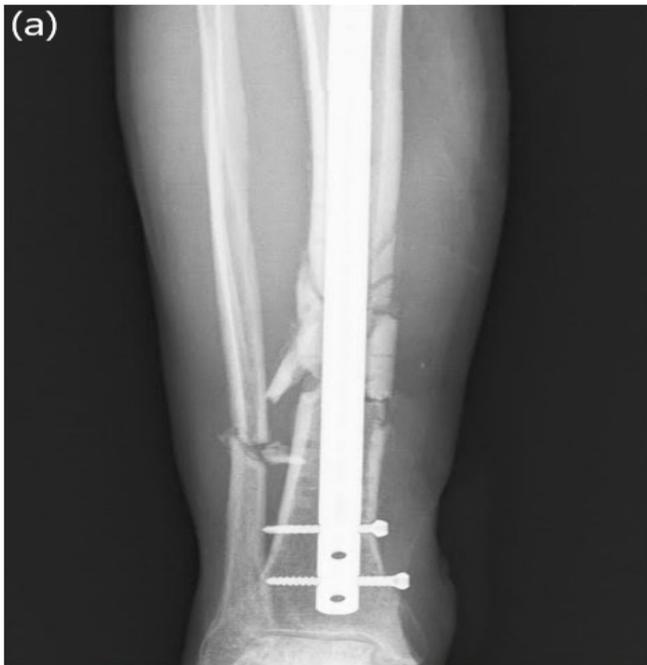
Immediate post-operative radiography of the control patient
